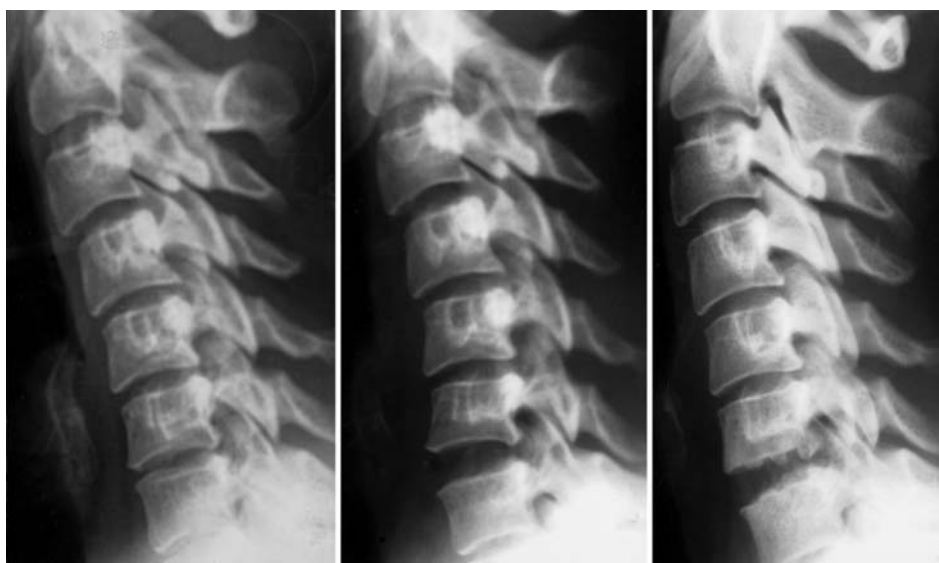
Radiographs obtained in a 36-year-old woman with left-sided C6–7 disc herniation. *Left:* Preoperative lateral radiograph revealing C6–7 disc space narrowing. *Center:* Lateral radiograph obtained 3 days postoperatively, demonstrating too much restoration of intervertebral height at C6–7. *Right:* Lateral radiograph obtained 5 months postoperatively, demonstrating bone ingrowth from both vertebral endplates into the empty CFCF cage placed at C6–7.
